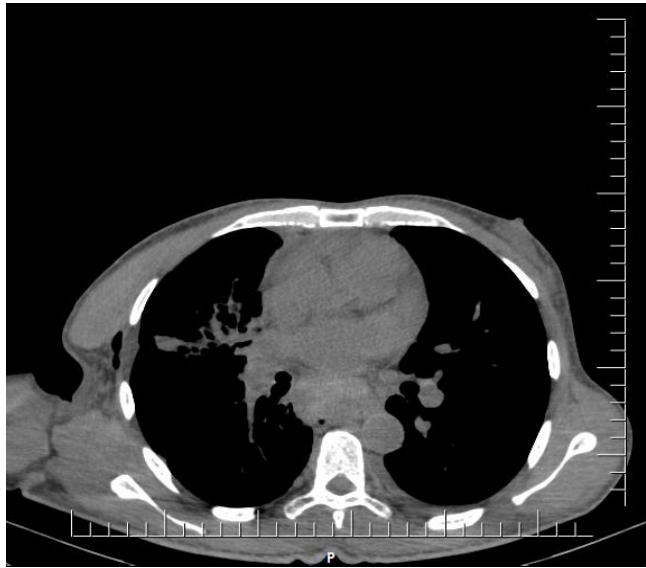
CT scan of the chest prior discharge. No residual fluid or blood. Small subcutaneous emphysema near the site of drainage tube insertion.
